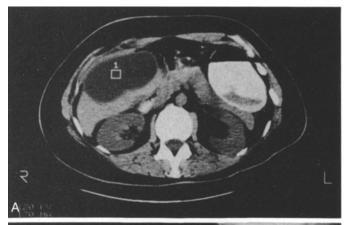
Unrecognized injury of an anomalous right duct during an "uneventful" cholecystectomy with onset of pain in the right upper quadrant 9 days later. A. CT scan shows a perihepatic fluid collection (bilioma) successfully treated by ultrasound-guided percutaneous drainage. The bile duct system was decompressed using a nasobiliary tube. B. Cholangiography, by injecting the tube, shows bile leakage (arrow) from the injured duct with prestenotic dilation. Patient was symptom-free with normal liver function tests 6 months after operation.
